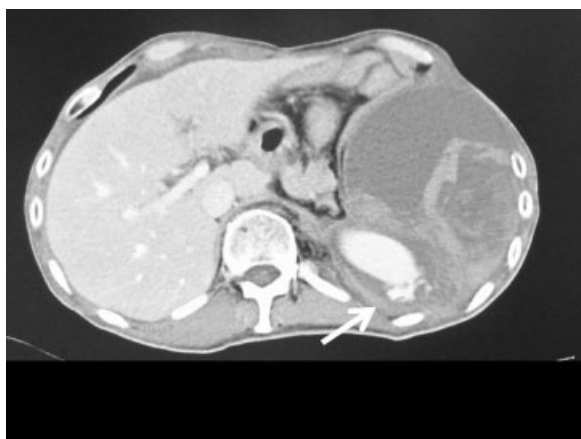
A computed tomographic scan demonstrating active contrast extravasation (arrow) and a massive hematoma around the graft.
